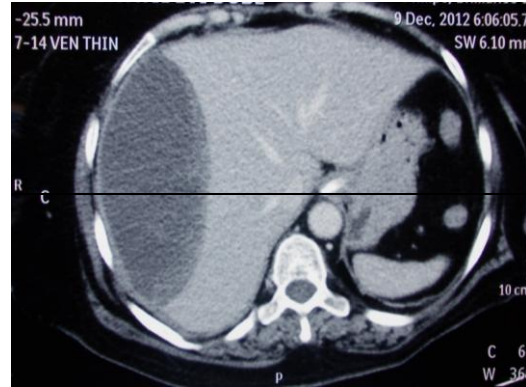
Post Op CT Scan Abdomen showing ISH.
